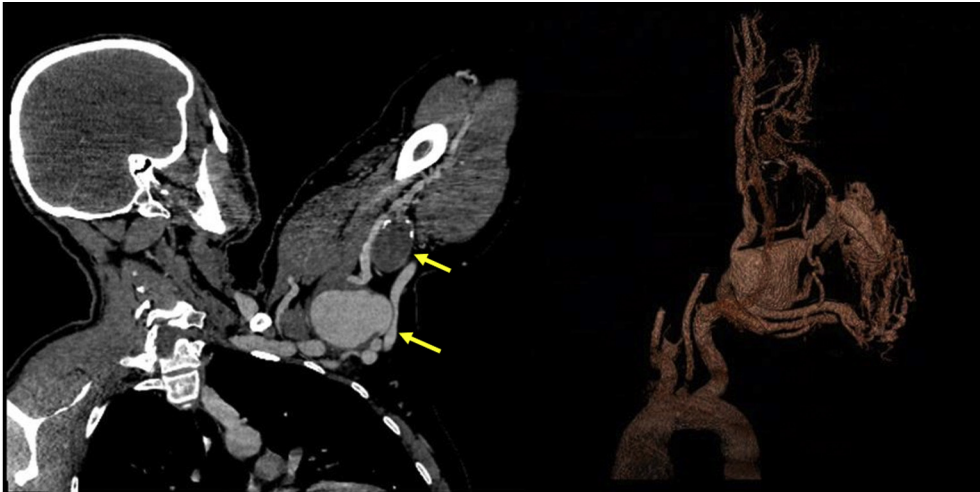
The CT angiography with multiplanar and volume rendering reconstructions. The *arrows* show the first big patent saccular aneurysm and the second saccular spontaneously occluded aneurysm. The whole arterial axis is patent.
